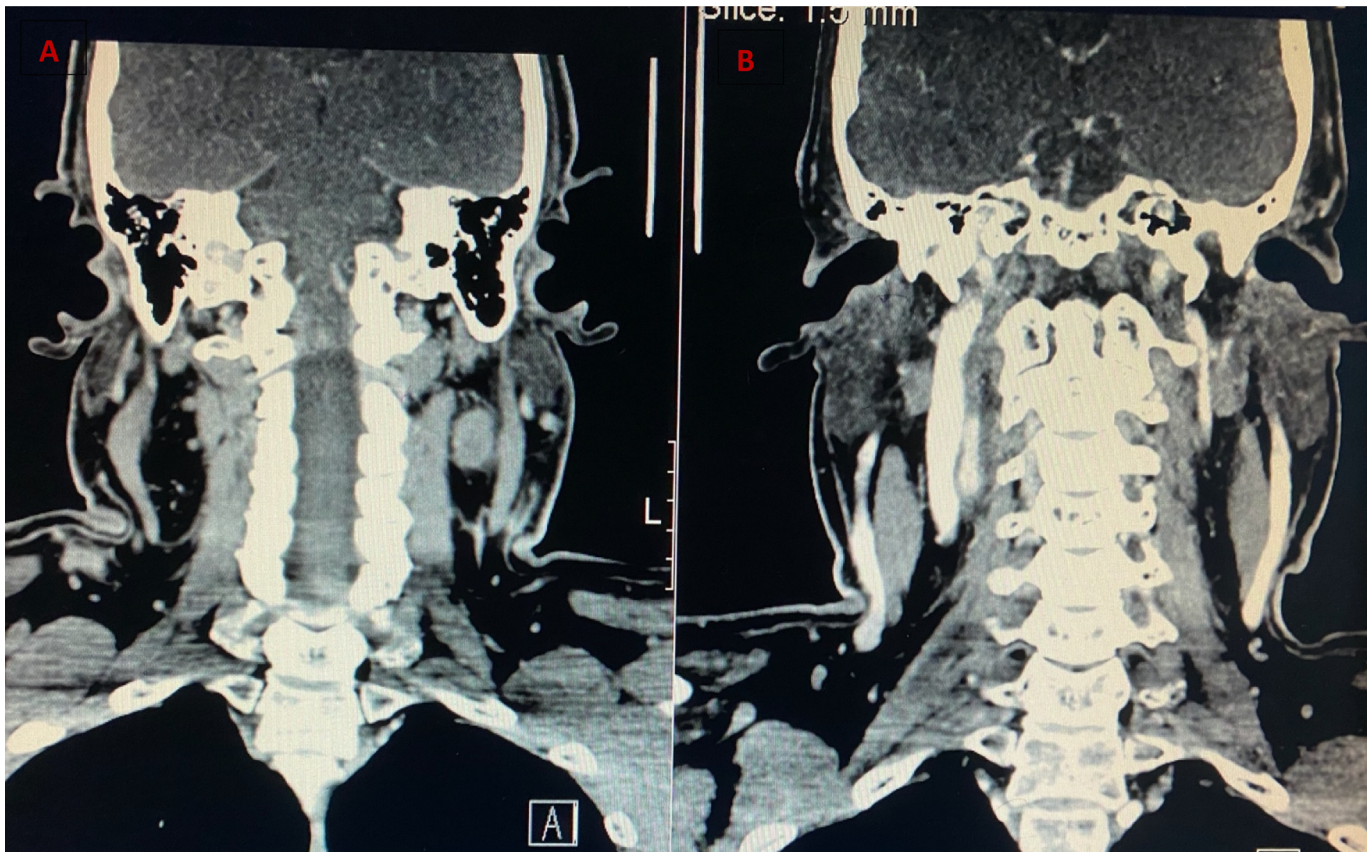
Coronal view of CT scan (A) before chemotherapy, (B) after chemoradiotherapy.
